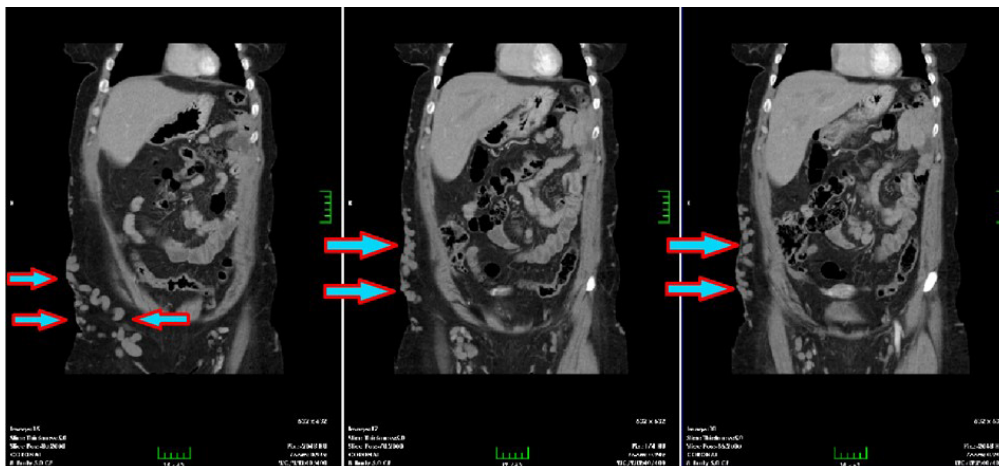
In I.V. contrast-enhanced CT sections taken in the axial plane; In order to provide venous system drainage secondary to infra-renal IVC partial agenesis, widespread tortuous venous vascular structures with increasing calibration and ectatic dilatation attract attention within subcutaneous adipose tissue planes in the right abdominal lower quadrant and pelvic level abdominal walls.
